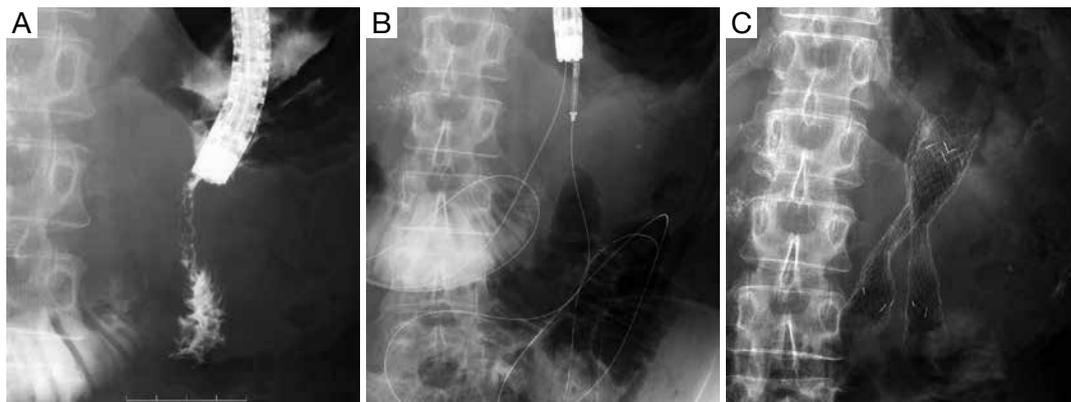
Stent placement for occluded palliative gastrojejunostomy. (A) Contrast study showing tumor-related obstruction of a gastrojejunostomy created for unresectable gastric cancer; (B) two guidewires have been inserted through the stricture into the afferent and efferent loops; (C) the final radiograph indicates successful placement of stents for both the afferent and efferent loops.
